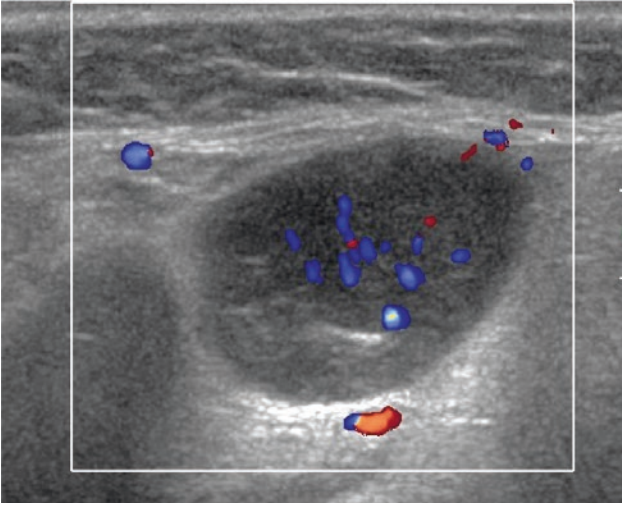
Lymphoma node that is enlarged, round, and does not have a hilum. These lymph nodes are usually homogeneous, with relatively low level internal echoes. They can be diffusely vascular on color Doppler
